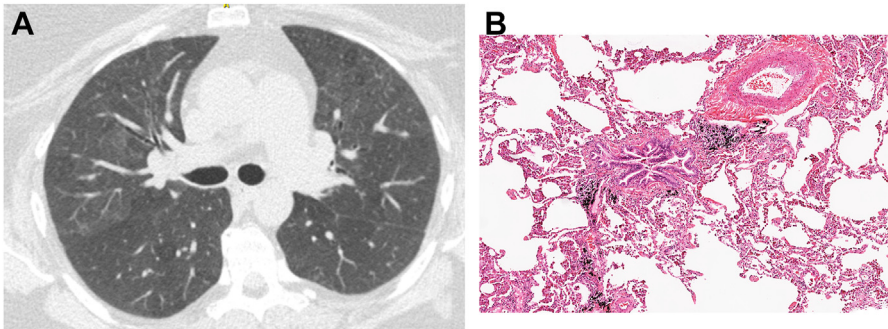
RB-ILD. (A) Axial CT image showing hazy ground-glass opacities involving anterior portions of the upper lobes. (B) RB-ILD shows less prominent collections of alveolar macrophages than in DIP, mainly localized to bronchiolar lumens and adjacent centriacinar alveolar spaces, with little or no interstitial fibrosis.
